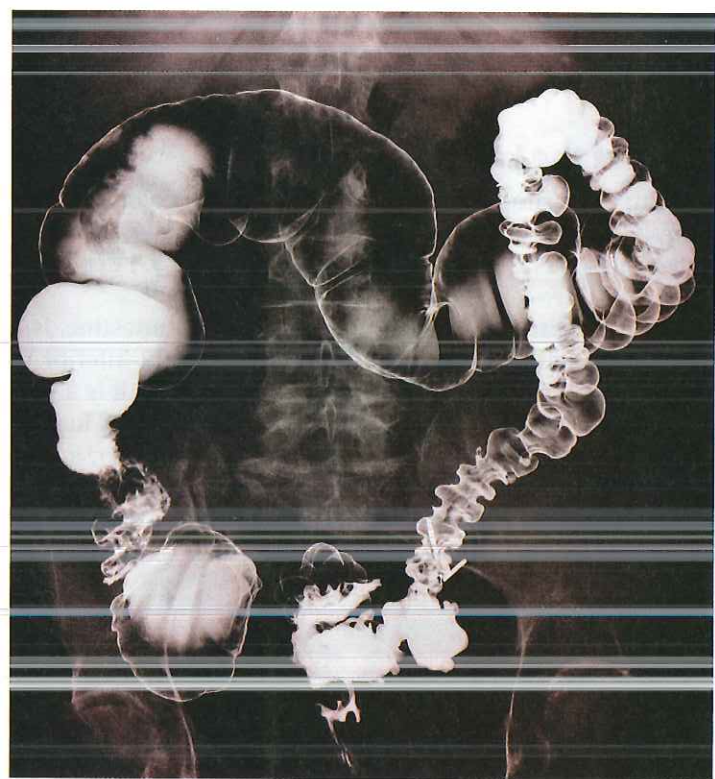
AP|R Radiograph of the large intestine containing a radiopaque substance that the patient ingested.
